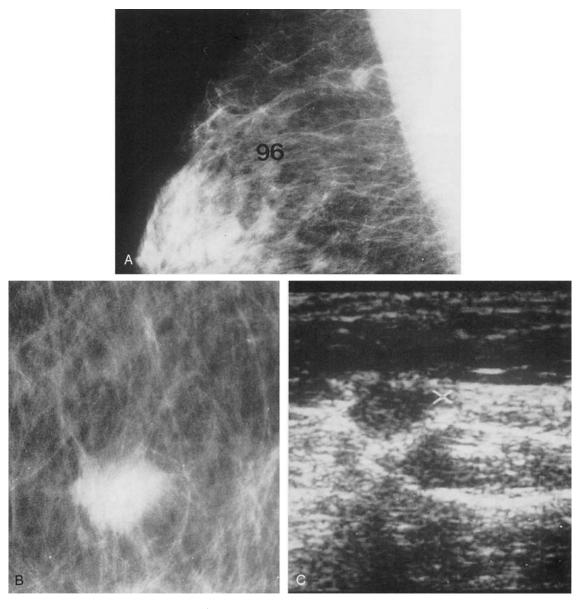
A and B, Right breast mediolateral oblique projection and microfocus magnification image. A solitary, ill-defined mammographically malignant tumor mass is seen with no associated calcifications. C, Ultrasound image of the tumor. D, See page 649.
